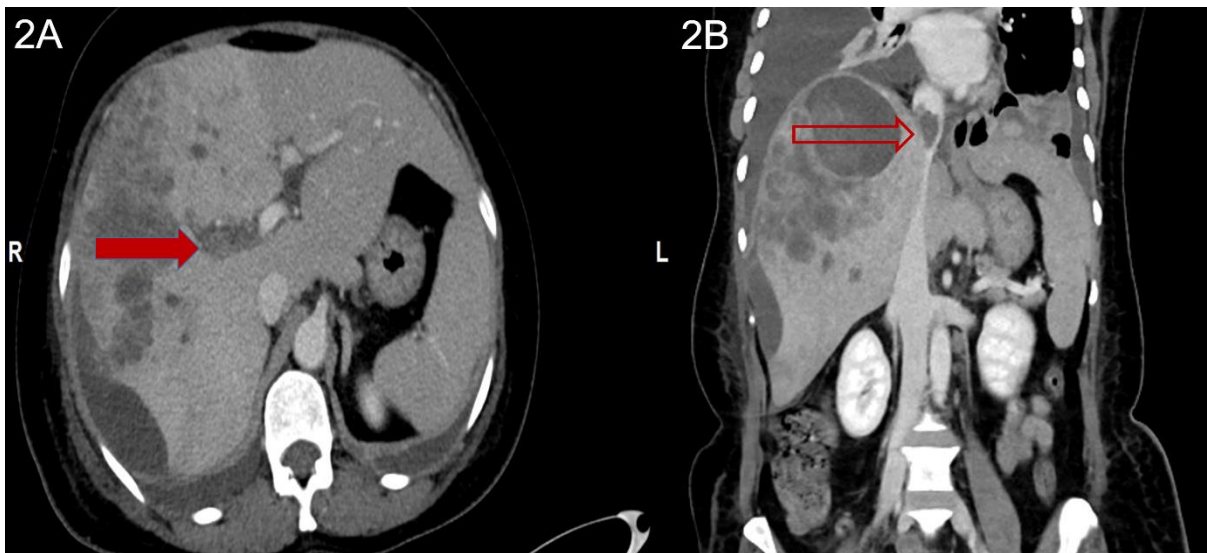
Contrast enhanced computed tomography (CECT) of the abdomen and the thorax. 2A- Axial section of portal Phase CECT of the abdomen and pelvis shows hypodense filling defect in the right branch of the portal vein (solid arrow). Normally enhancing left branch of the portal vein is seen. 2B- Coronal reformation of the venous phase of CECT abdomen and pelvis reveals a hypodense filling defect in the supra-hepatic segment of the inferior vena cava (IVC) suggestive of thrombus (arrow).
